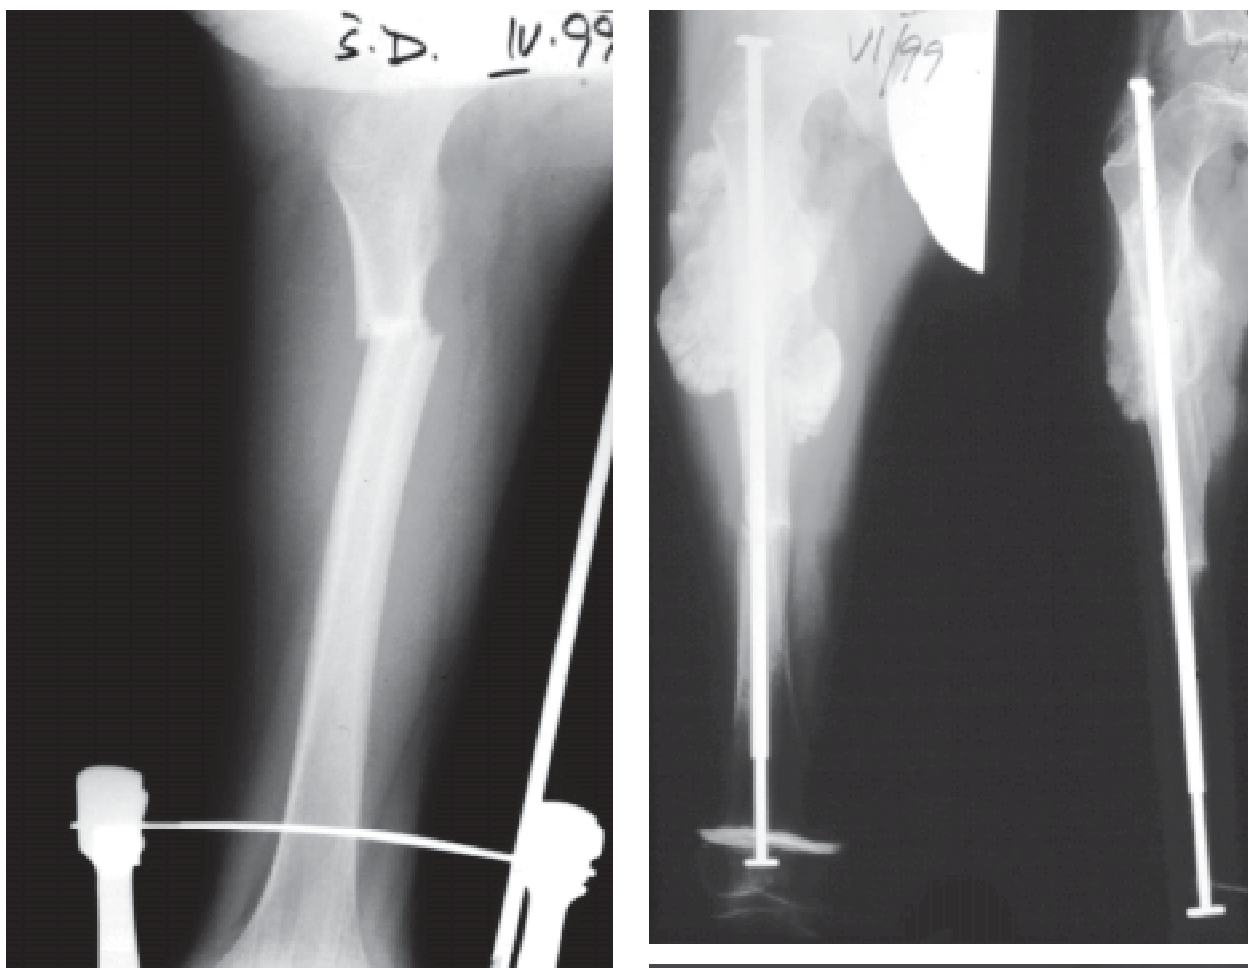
(a,b,c) Fracture of the femur conservatively treated (a); development of hyperplastic callus formation gives rise to the question of possible osteosarcoma (b); CT imaging could help establish correct diagnosis (see text). (Courtesy Head Doctor Boštjan Baebler, Ljubljana).
